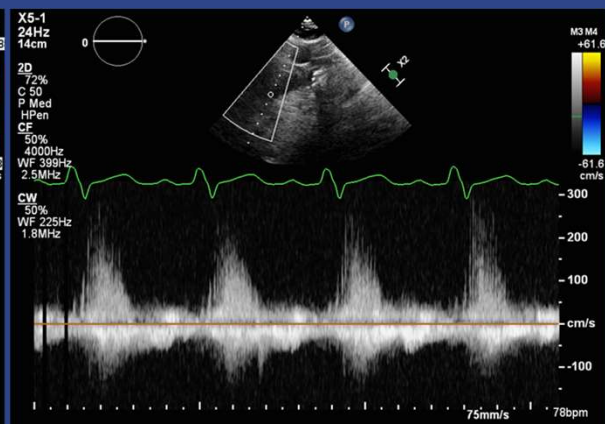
RSB CW Doppler across post-op day 1 TAVR, from author's clinical collection, di-identified (M.Trump, 2025)
